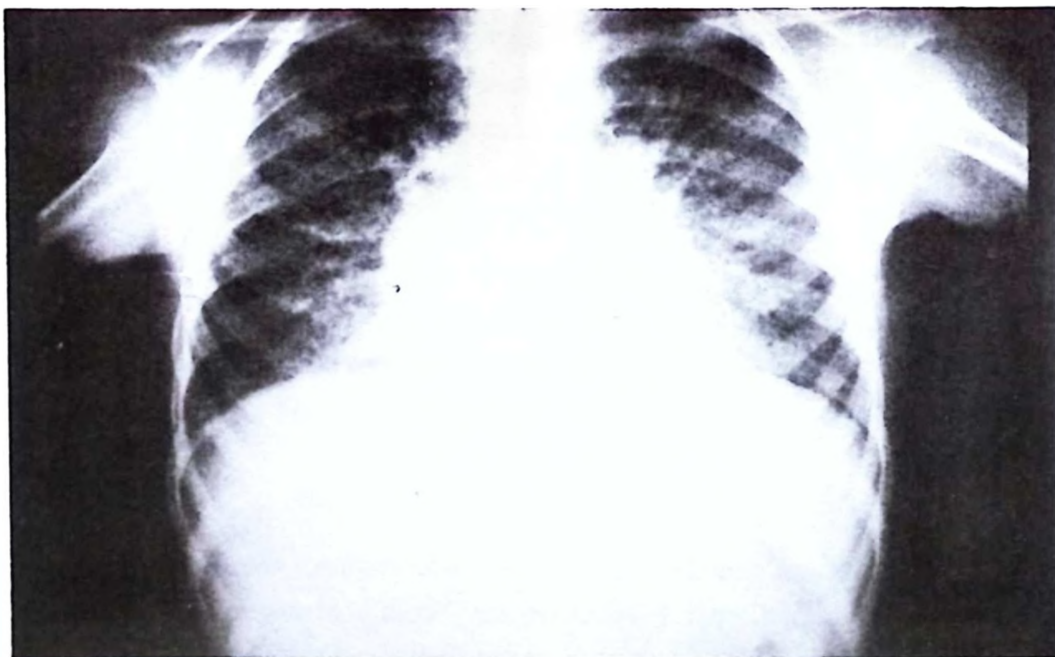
Chest x-ray of the patient. Bilateral, diffuse calcified micronodules.
